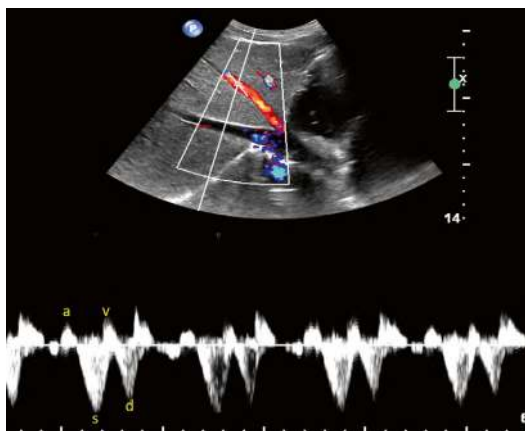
Normal spectral Doppler waveform of hepatic veins with its four components
